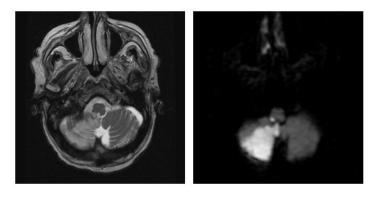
Right posterior-inferior cerebellar artery stroke. T2- and diffusion-weighted MRI sequences. Gonzalez-Gay et al (2009) ⁽²²⁾.
